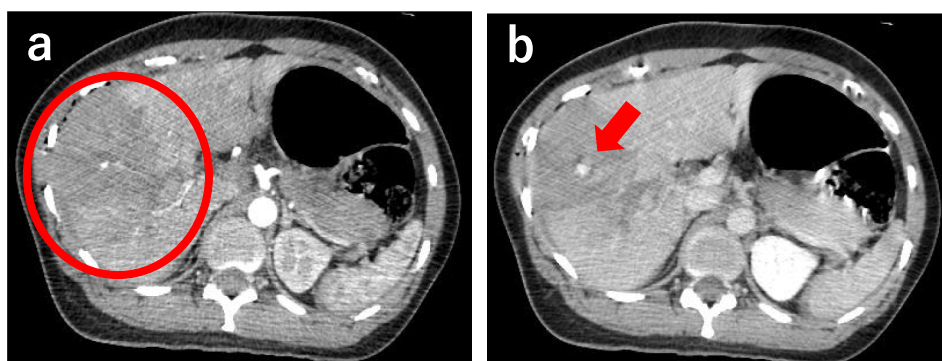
Abdominal contrast enhanced CT on arrival at our hospital.
